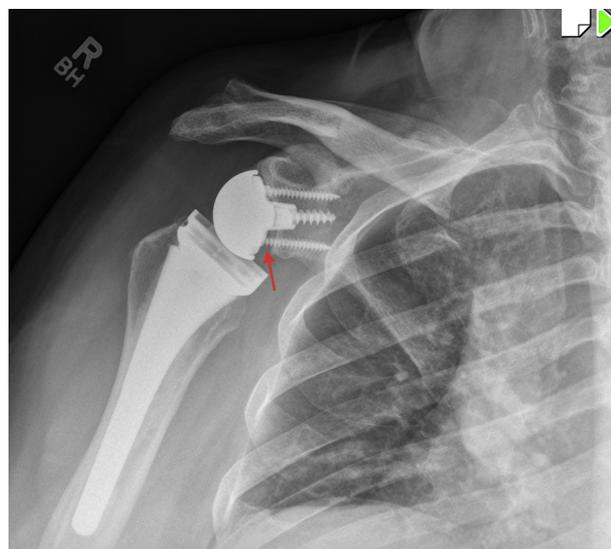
Postoperative radiograph of a 67-year-old patient with a 155° prosthesis demonstrates grade 4 scapular notching. Note that the notching (*red arrow*) extends to the inferior screw.
